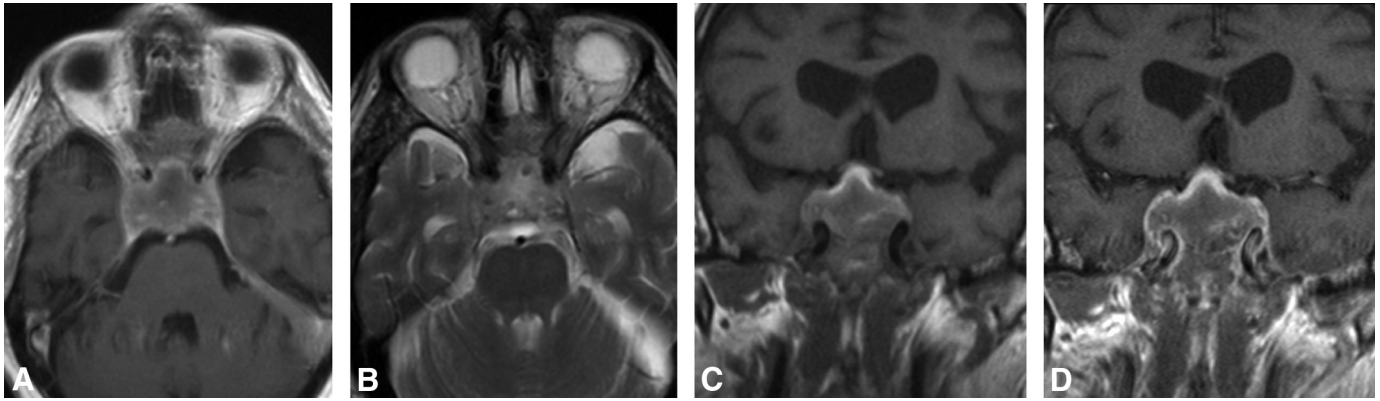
Apoplexy. Axial postgadolinium T1WI (A) and T2WI (B), and coronal T1WI (C) and postgadolinium T1WI (D) in a patient with apoplexy. An 82-year-old man with sudden onset of panhypopituitarism. MR imaging of the brain (A–C) demonstrates a markedly enlarged pituitary gland with heterogeneous signal intensity; the optic chiasm is cranially displaced. The postgadolinium T1WI (D) demonstrates peripheral enhancement, albeit difficult to appreciate due to the intrinsic high signal intensity on T1WI.
